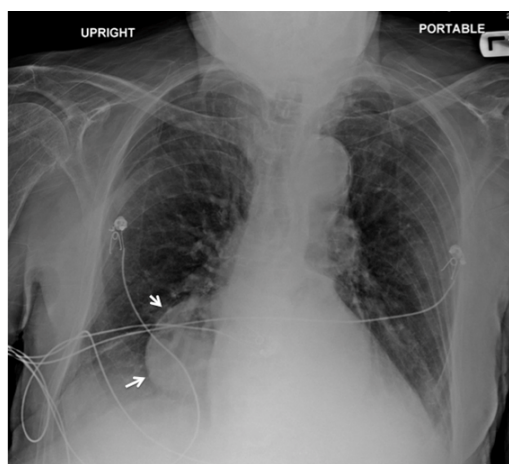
Portable chest X-ray in AP view showing a large rounded mass projecting beyond the right cardiac border due to a large hiatal hernia.
